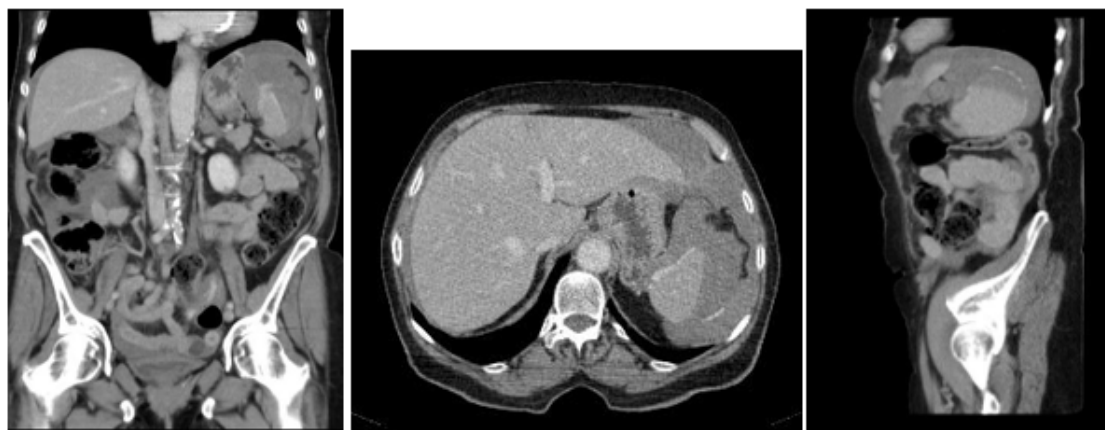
Initial CT abdomen.
